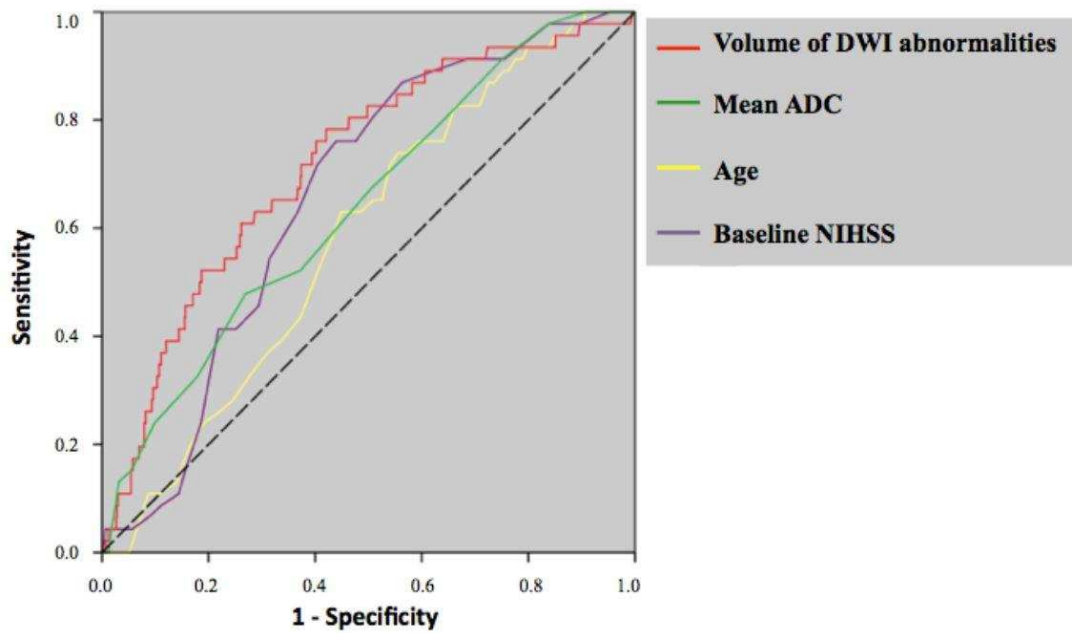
Receiver operating characteristic curves with the 4 quantitative variables independently associated with s-HT (age, baseline NIHSS, volume of DWI abnormality, mean ADC). s-HT: symptomatic hemorrhagic transformation. NIHSS: national institutes of health stroke scale. DWI: diffusion-weighted imaging. ADC: apparent coefficient diffusion.
